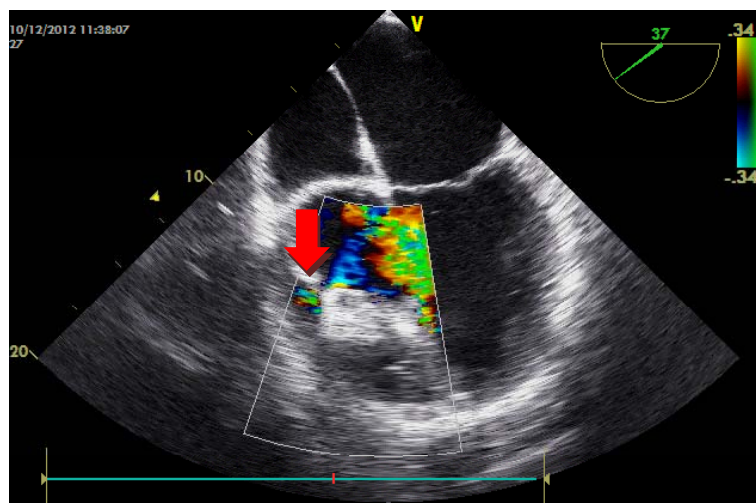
Transesophageal exam images of Amplatzer muscular ventricular septal defect (VSD) device after VSD closure with a small residual shunt.
